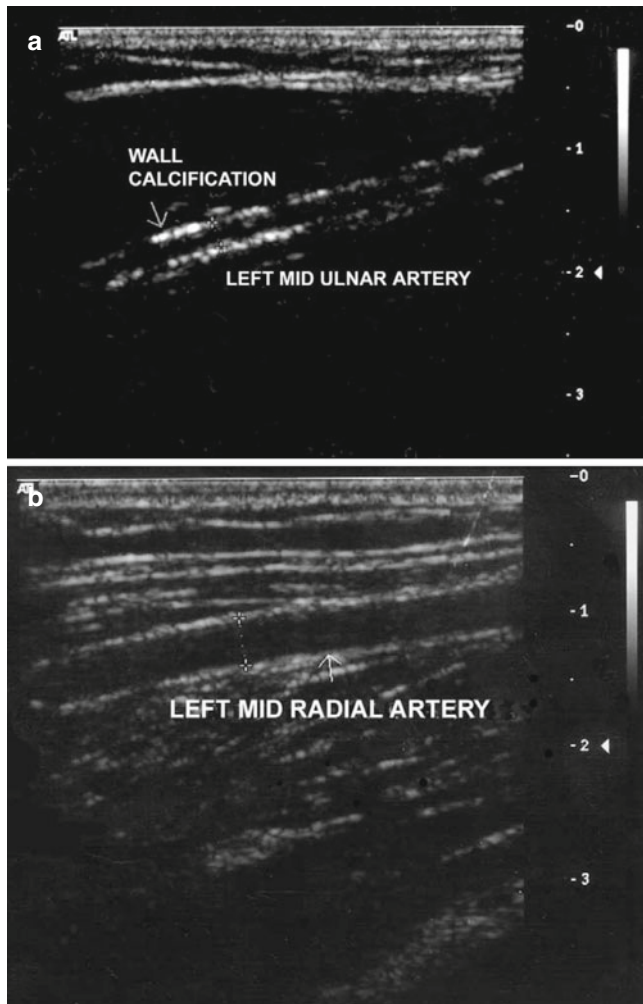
Ultrasound detection of arterial calcification. (a) Demonstration of wall calcification (*arrow*) of the ulnar artery. (b) Ultrasonography image of a normal radial artery (*arrow*) in the same patient. (used with permission from 7)
